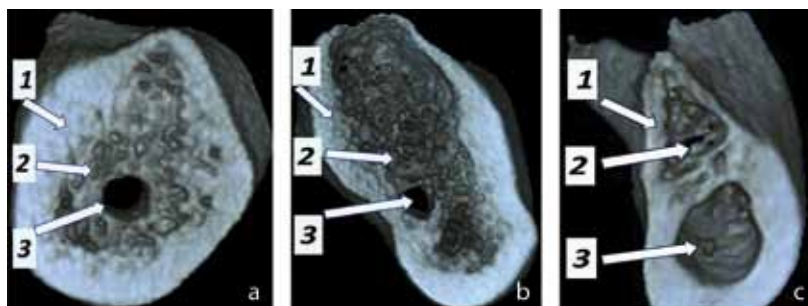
Cone-beam computed tomography cross-section of the alveolar part of the mandible of a healthy child (a) and a child with experience of type 1 diabetes from 1 year to 5 years (b) and a child with experience of type 1 diabetes more than 5 years (c): 1 – cortical lamina, 2 – bone trabeculae, 3 – mandibular canal
